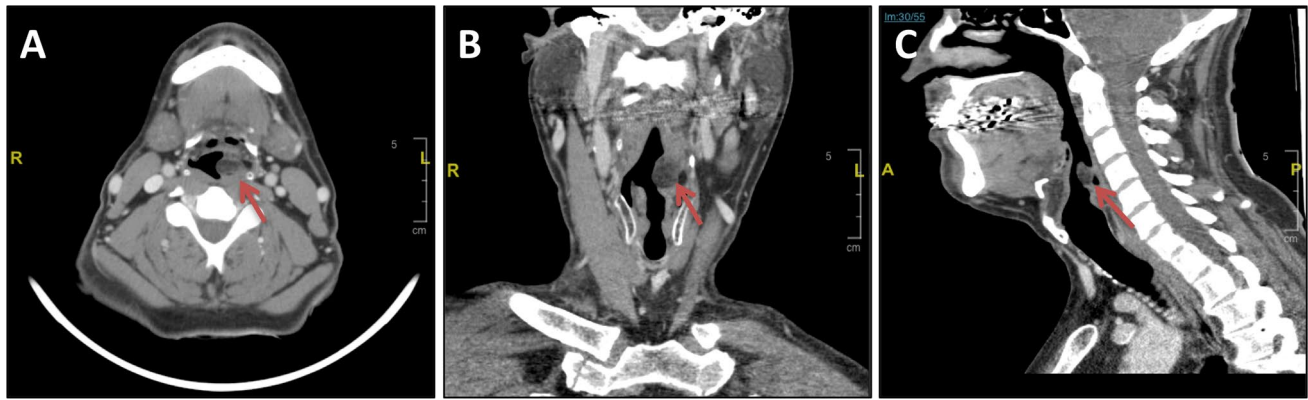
CT neck with contrast depicting the supraglottic mass in a axial, b coronal, and c sagittal views. The red arrow indicates the mass.
